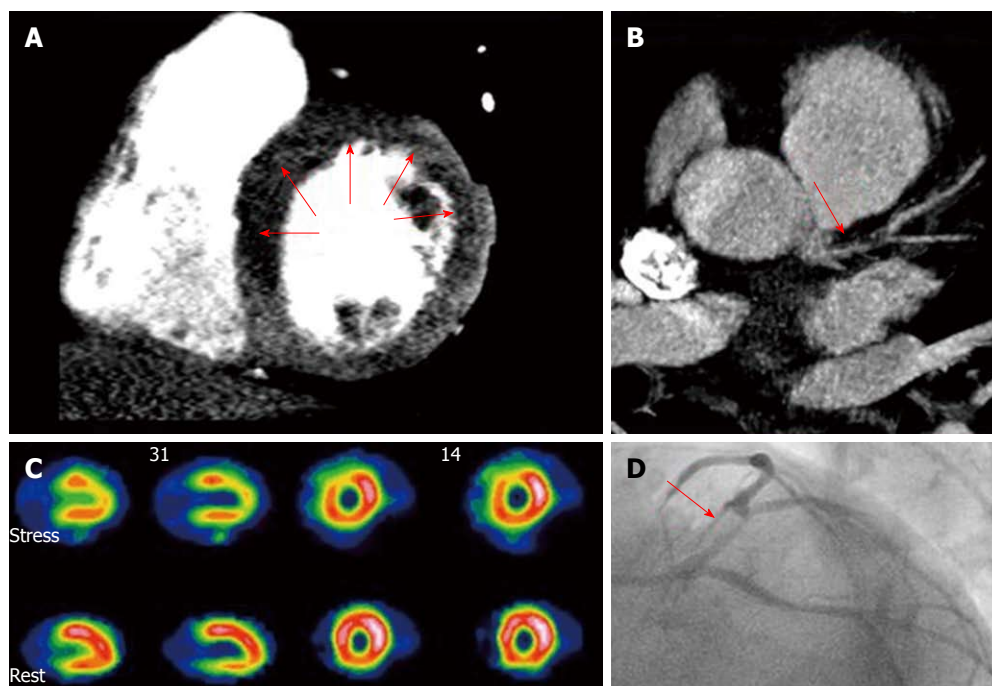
Combined assessment of myocardial perfusion at pharmacological (adenosine) stress and coronary angiography within a single-session cardiac computed tomography. Cardiac computed tomography (CT) (panels A and B) showed diminished perfusion of the left ventricle anterior and septal wall (A, arrows) and a significant lesion at the proximal left anterior descending artery (B, arrow), findings confirmed by single photon emission computed tomography (SPECT) (C) and invasive coronary angiography (D, arrow). A: CT perfusion (stress); B: Coronary CT angiography; C: SPECT myocardial perfusion imaging; D: Invasive angiography. With permission of Blankstein *et al*^[21], *J Am Coll Cardiol* 2009; 54: 1072-1084.
